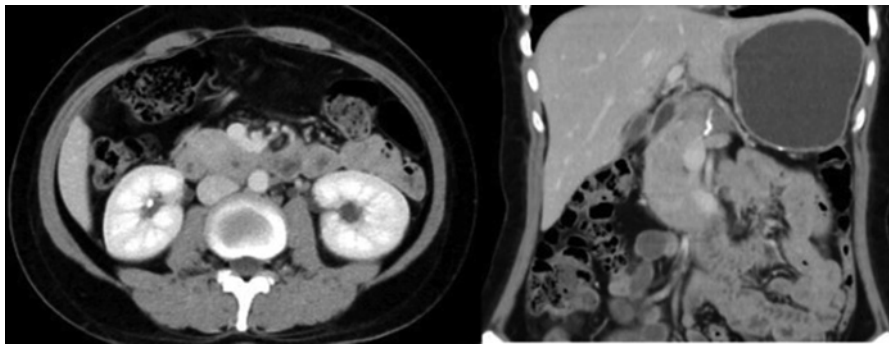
Contrast-enhanced CT findings 2 years after surgery. There has been no tumor recurrence.
